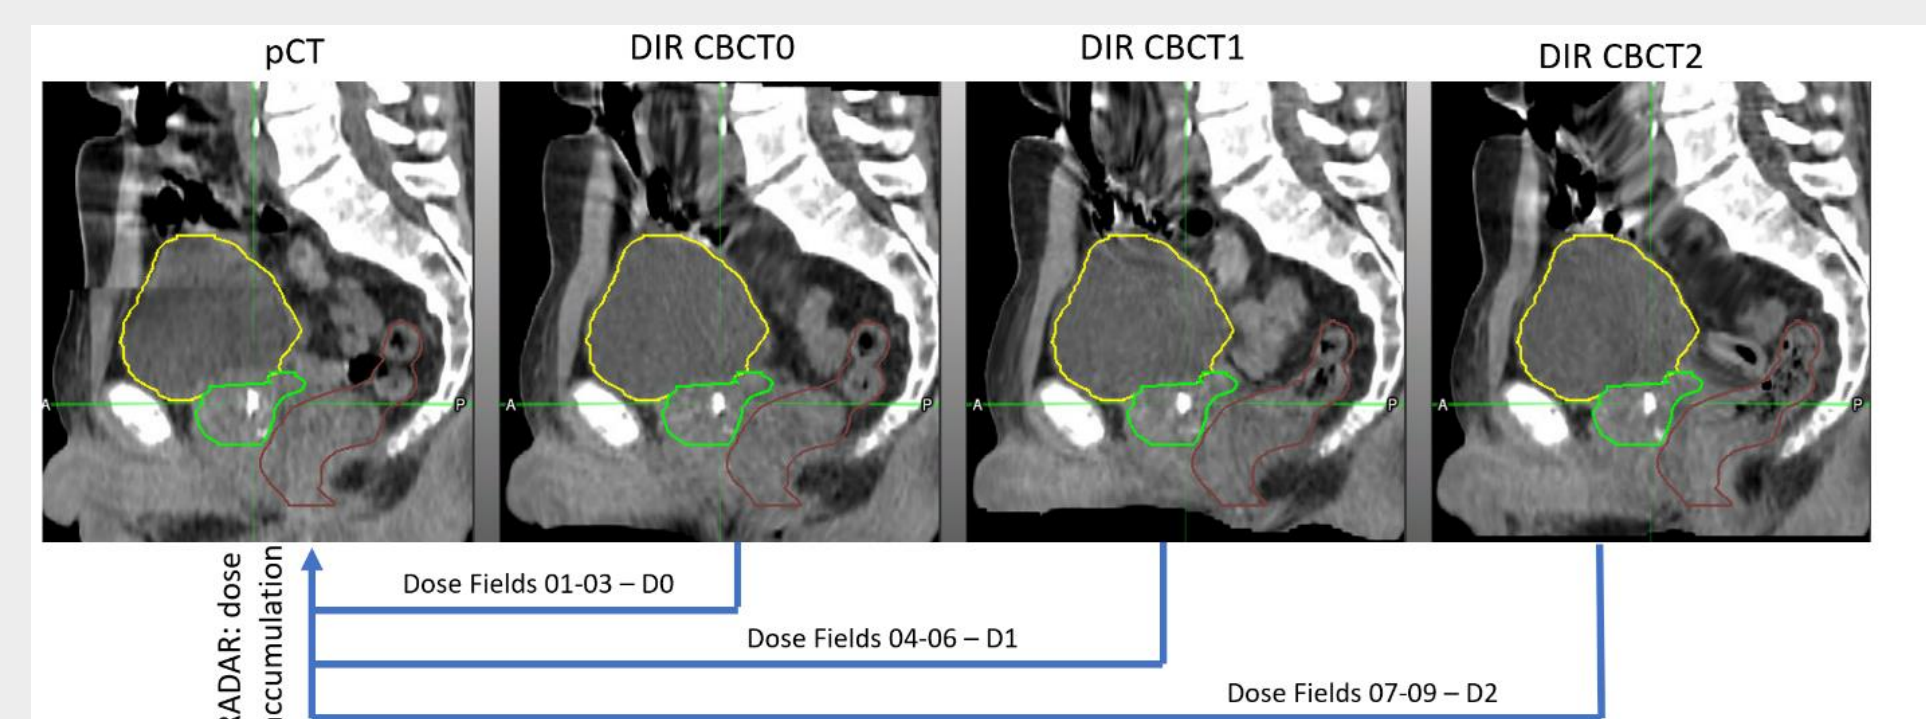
C-DIR was performed to register in CBCT to planning CBCT, as basis for dose accumulation. Contours outline the target volume - CTV prostate (green) and adjacent organs at risk, including the bladder (yellow) and rectum (brown).
